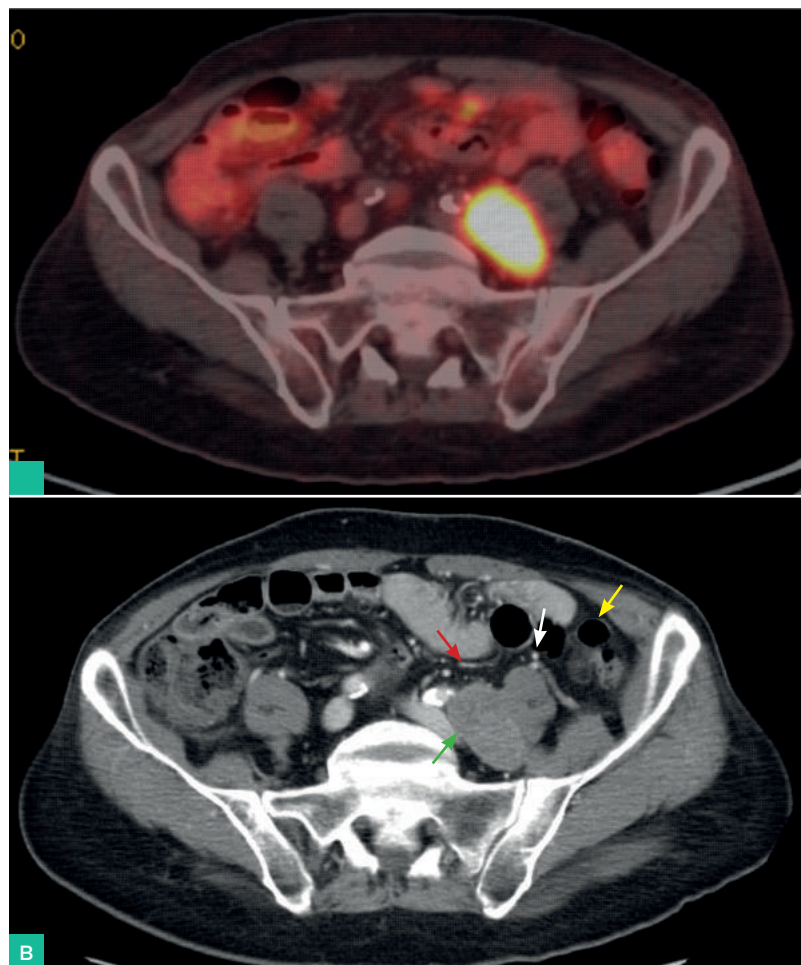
A. PET-CT with FDG. B. abdominal CT with contrast where you can see the retroperitoneal mass compatible with the adenopathic conglomerate in the left iliac chain (green arrow). You can also see that the lesion cannot be accessed from the front due to the interposition of the descending colon (yellow arrow) and small intestine loops. Ureter (red arrow) and gonadal vessels (white arrow).
